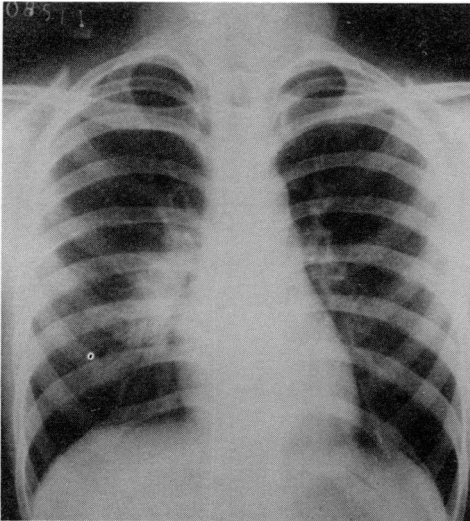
First chest X-ray film (Case 1).
